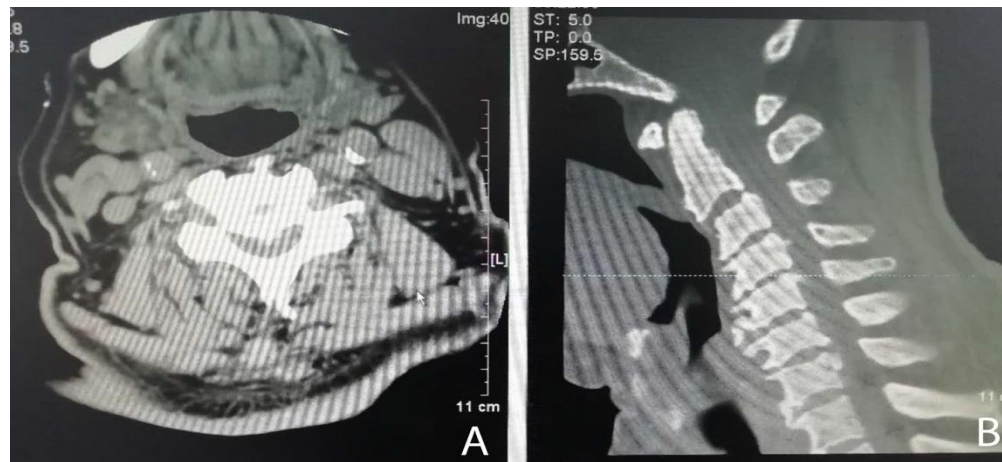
Preoperative cervical CT scan. (A) Cross-section: hypertrophy of the pyramidal edge and intervertebral facet joints. (B) Sagittal plane: Cervical curvature and poor alignment, C2-7 intervertebral disc protruding to the back.
